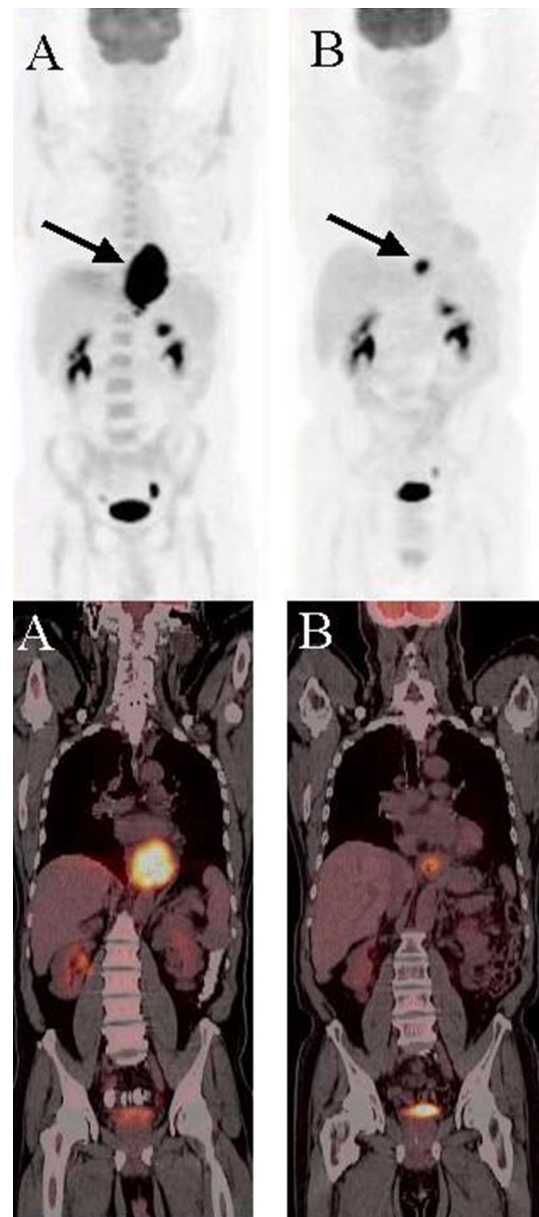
58-year-old man with moderately differentiated adenocarcinoma of the distal esophagus. PET/CT at baseline (a): marked focal uptake of FDG is identified in gastroesophageal tumor (*arrow*). Follow-up PET/CT (b) showing partial response to therapy with decrease in extent and degree of FDG uptake (*arrow*). Baseline SULpeak = 17.9; follow-up SULpeak = 5.2
